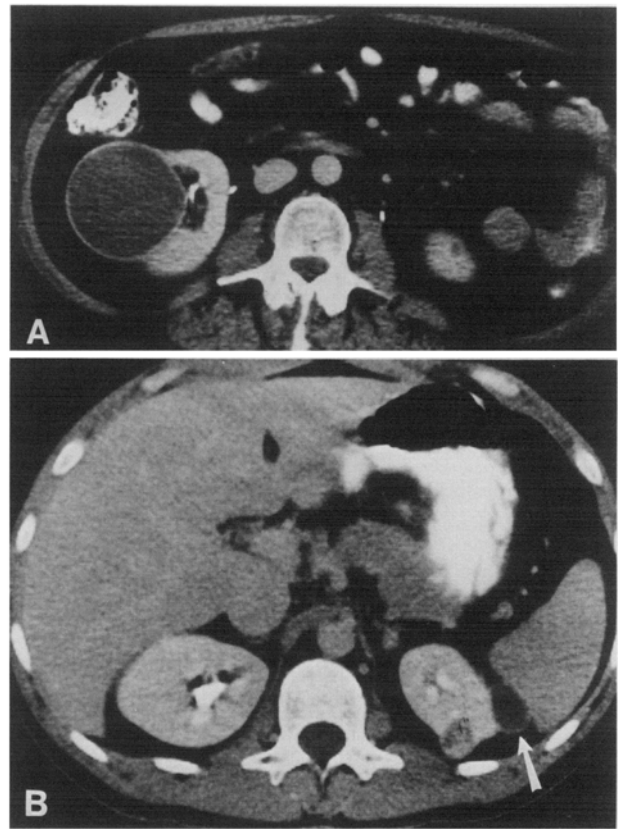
Two cases of wall thickening (category III). A Benign cyst. Enhanced CT demonstrates a well-circumscribed cystic mass in the right kidney with diffuse, uniform wall thickening. Because cystic renal cell carcinoma could not be excluded, the mass was removed. Pathologic examination showed no evidence of malignancy. B Renal cell carcinoma. Enhanced CT scan shows a cystic mass (12 HU) with uniform wall thickening (arrow) in the left kidney. A second mass posteriorly was felt to be a solid malignant tumor. At surgery both masses were renal cell carcinoma.
